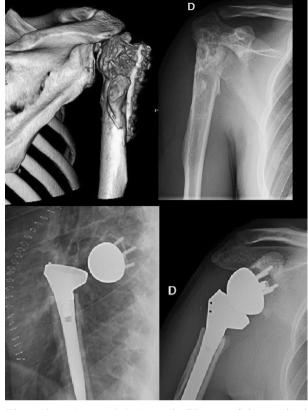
Images 1-4. Image 3, CT scan of the proximal humerus fracture's sequelae in a 20-year-old man. Image 4, X-ray of the proximal humerus fracture's sequelae in the same patient. Image 5, dislocation after RSA. Image 6, RSA after revision surgery.
